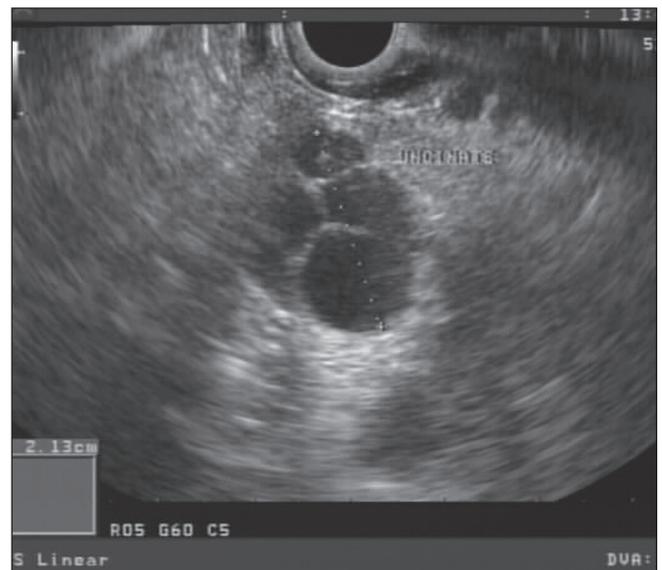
Branch-type intraductal papillary mucinous neoplasia. An abdominal computed tomography scan of a 63-year-old man undergoing evaluation for right lower quadrant abdominal pain. A hypodense lesion was seen in the head of the pancreas. Endoscopic ultrasound demonstrated a cluster of cysts in the uncinus process measuring 2 cm in size. The remainder of the pancreas and the main pancreatic duct were normal. This lesion is compatible with a branch-type intraductal papillary mucinous neoplasia and will be re-evaluated one year later
